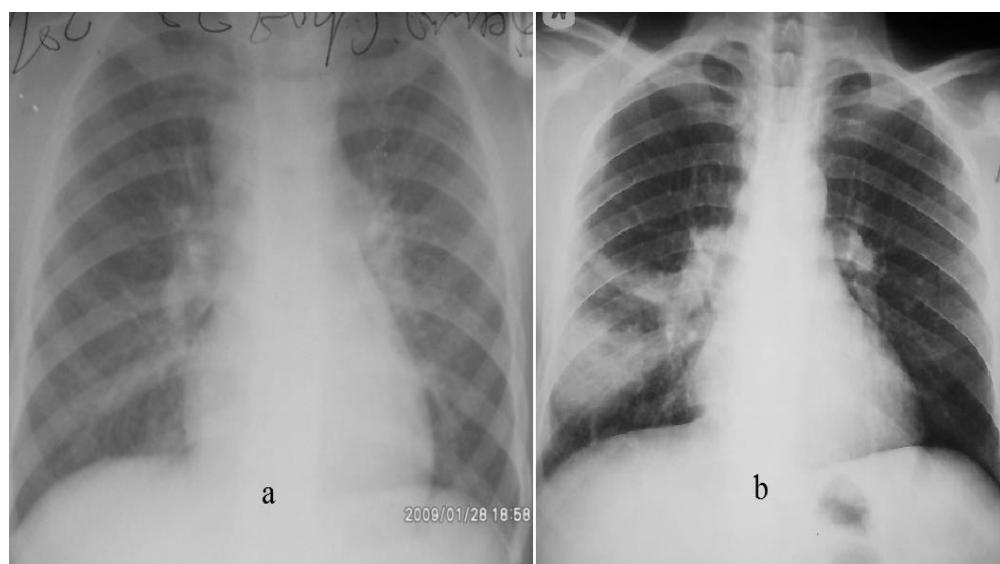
Chest radiographs in primary pulmonary tuberculosis showing:
